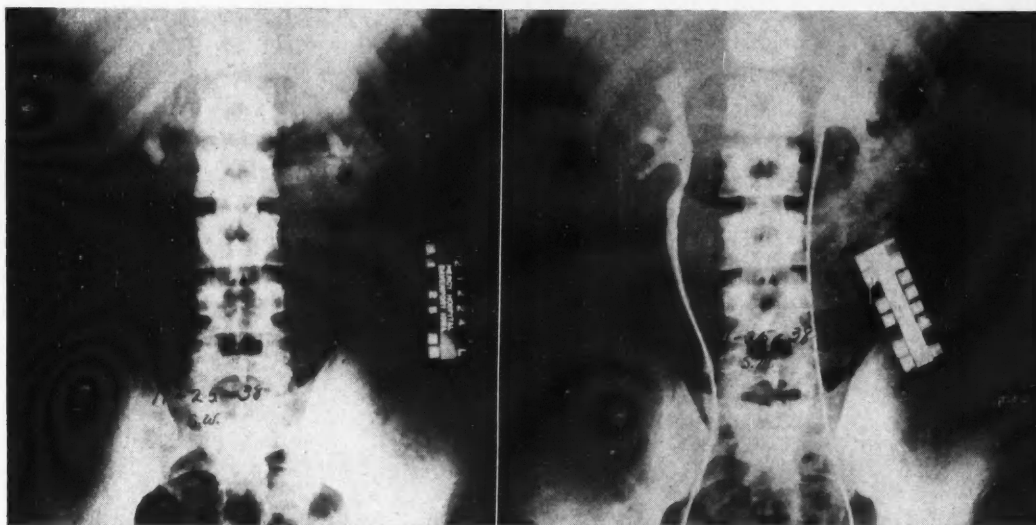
Plain film and retrograde pyelograms in a patient who had absolutely no evidence of bone changes or bone symptoms and who consulted a physician simply because of pyuria. Examination showed the presence of bilateral renal calculi, blood calcium of 13.7 mg. per 100 cc., and blood phosphorus of 2.7 mg. per 100 cc. These are the typical blood findings in hyperparathyroidism. In addition the patient had a urinary calcium output of over 600 mg. per 24 hours. The parathyroid glands were explored and an adenoma found and removed. Following this, under general care for infection and on dietary therapy for phosphate calculi, the urinary calculi disappeared.
